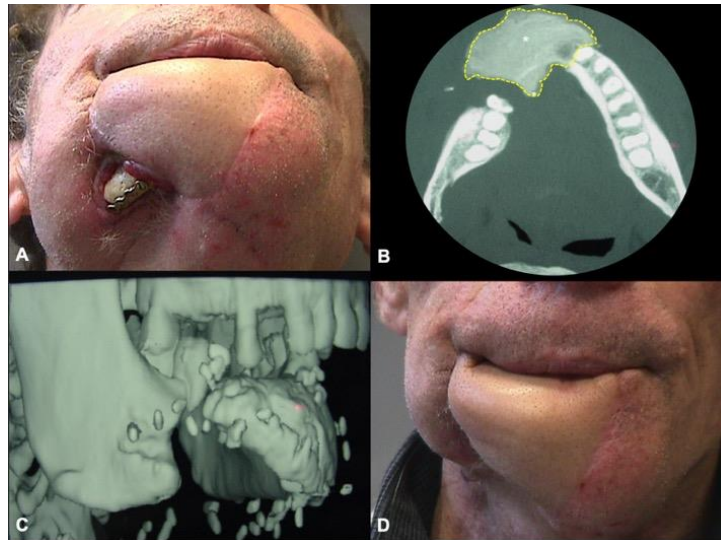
A):* Bone graft exposure 6 months after surgery. The graft is exposed in the area not covered by periosteum paddle; *B):* CT scan of the mandible performed after revision surgery for bone graft removal. A large amount of regenerated bone is evident; *C):* CT 3D-reconstruction shows multiple areas of neo-ossifications; *D):* Morphologic result after revision surgery: the profile of the mandibular arch has not been significantly changed after bone graft removal.
